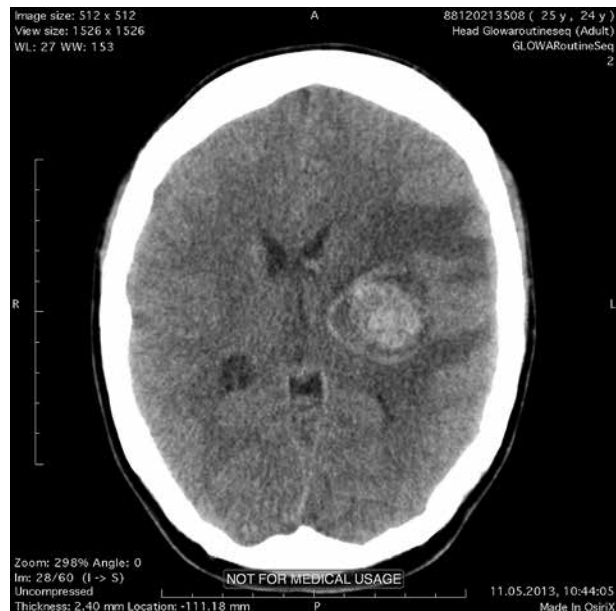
CT scan of the brain showing a mass 3.5 cm × 3.5 cm × 3.4 cm in size
